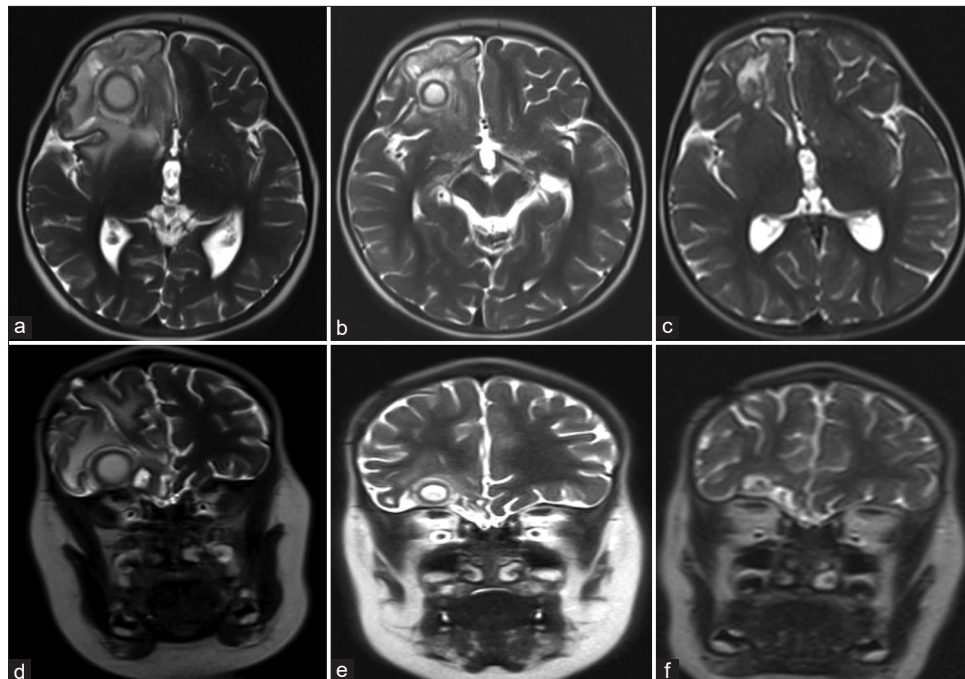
T2 MRI following aspiration and drain placement of the right frontal giant abscess at discharge (a) axial and (b) coronal, at 6 weeks follow-up (c) axial and (d) coronal, and at 3 months follow-up (e) axial and (f) coronal. There is progressive improvement in cerebral edema, mass effect, and ultimately obliteration of the abscesses.
